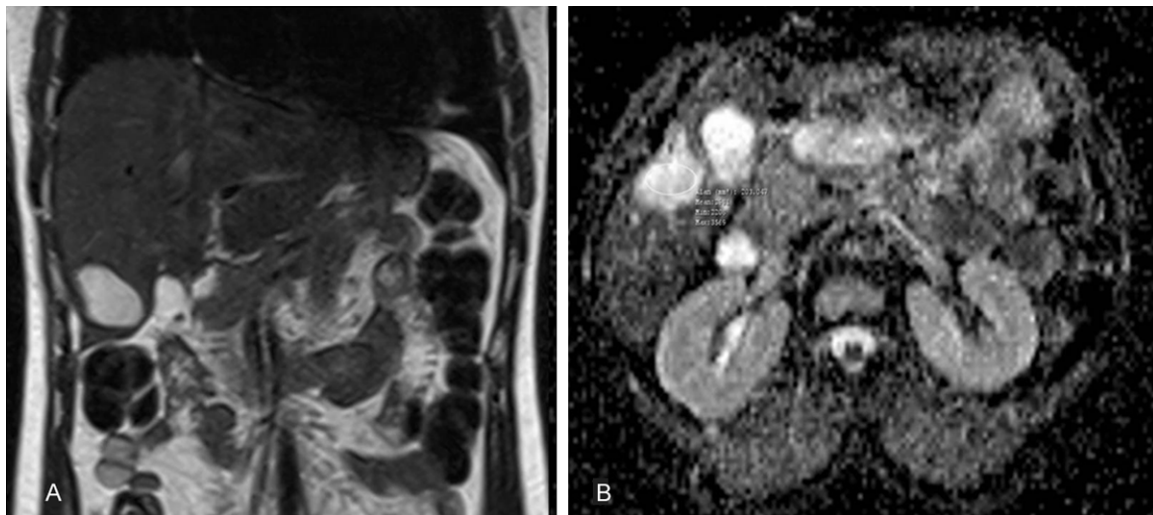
Magnetic resonance images of 37-year-old female patient with postoperative residual cavity treated with open partial cystectomy and external drainage for liver hydatid cysts about 12 months ago. A. Axial T2-weighted fast spin-echo MRI. B. ADC map show postoperative residual cavity in segment 6 of the liver. ADC value of postoperative residual cavity is $2.63 \times 10^{-3} \text{ s/mm}^2$.
